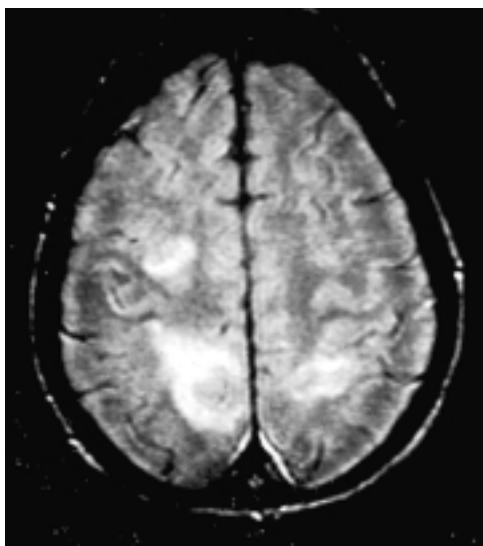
23-year-old female with history of SLE, antiphospholipid antibodies and stroke. Image obtained on 1.5 Tesla MRI Scanner (TR = 2000, TE = 30). Note two lesions in the patient's left parietal region and one small lesion in the right parietal region.
